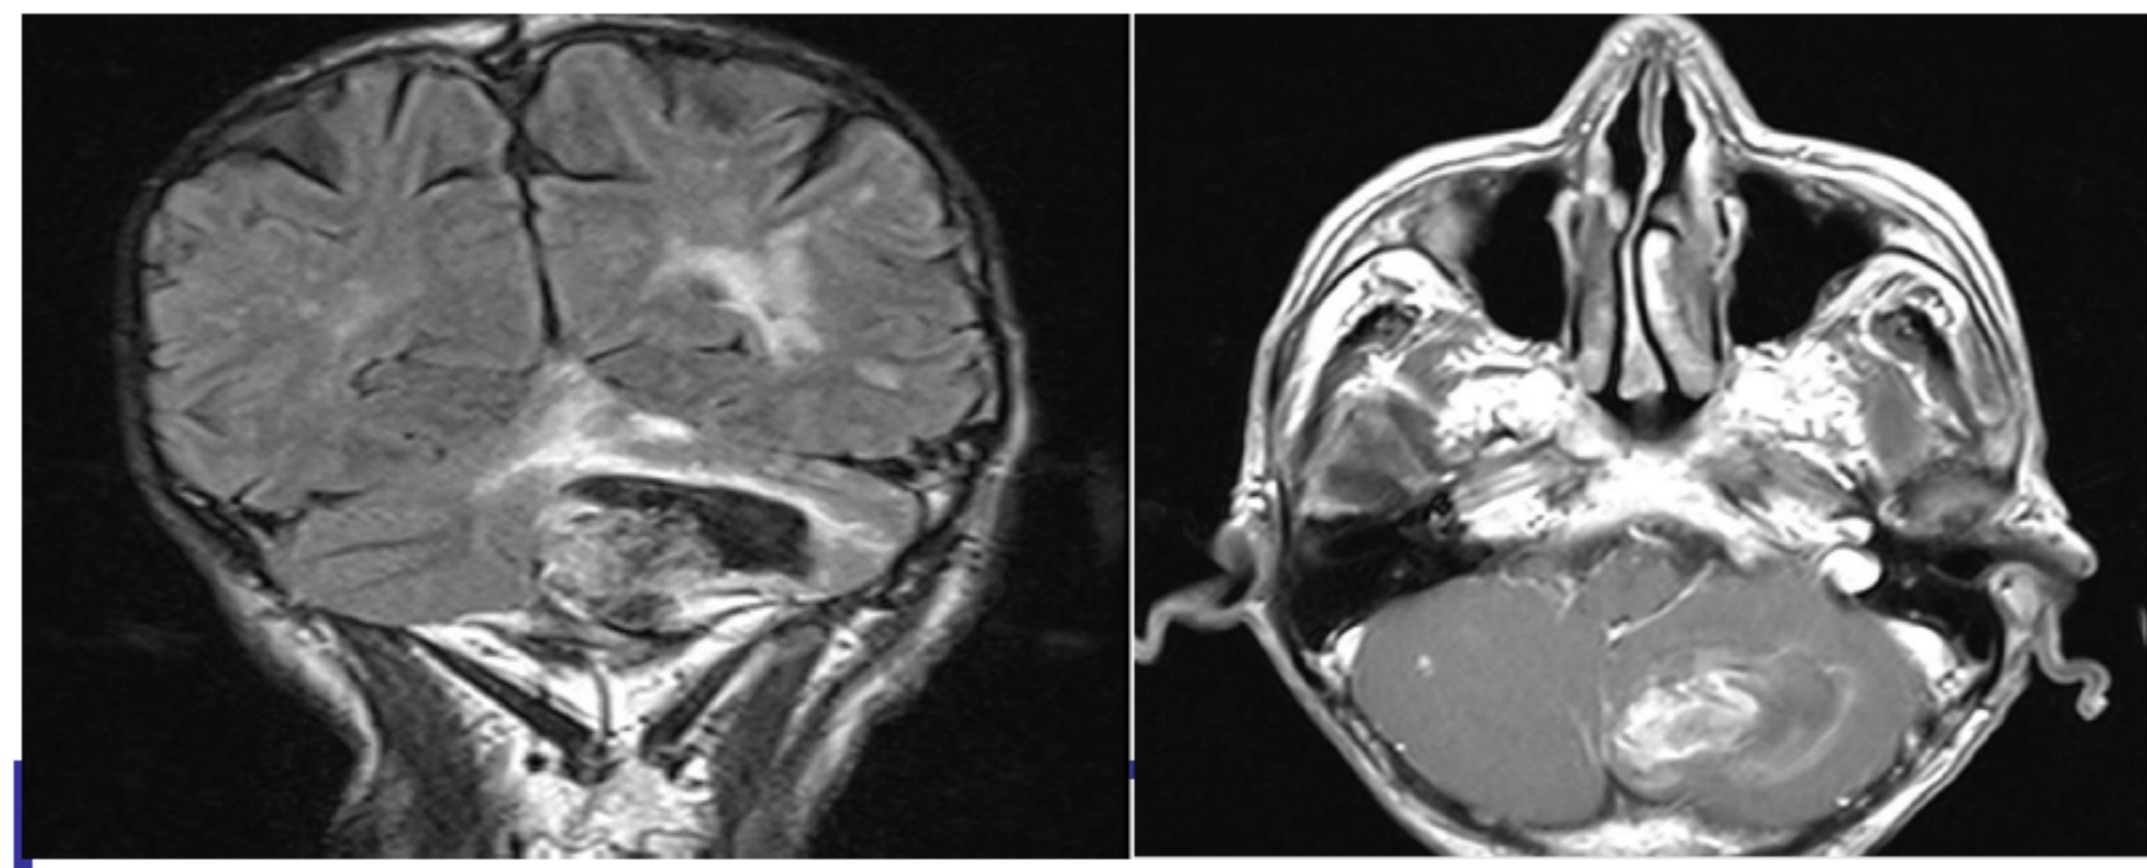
Views of magnetic resonance imaging of the brain which demonstrated a ring-enhancing lesion to the cerebellum accompanied by surrounding edema and compression of the fourth ventricle.
